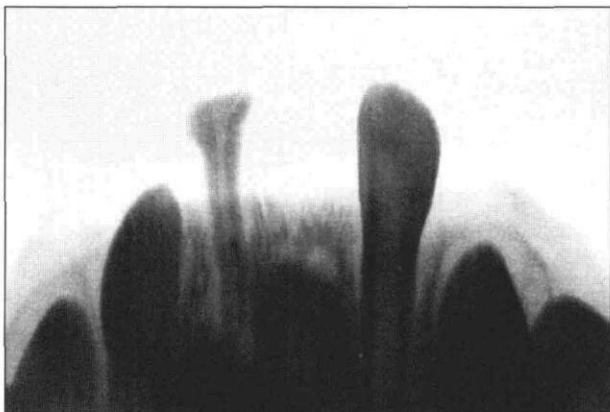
Radiographic presentation.
